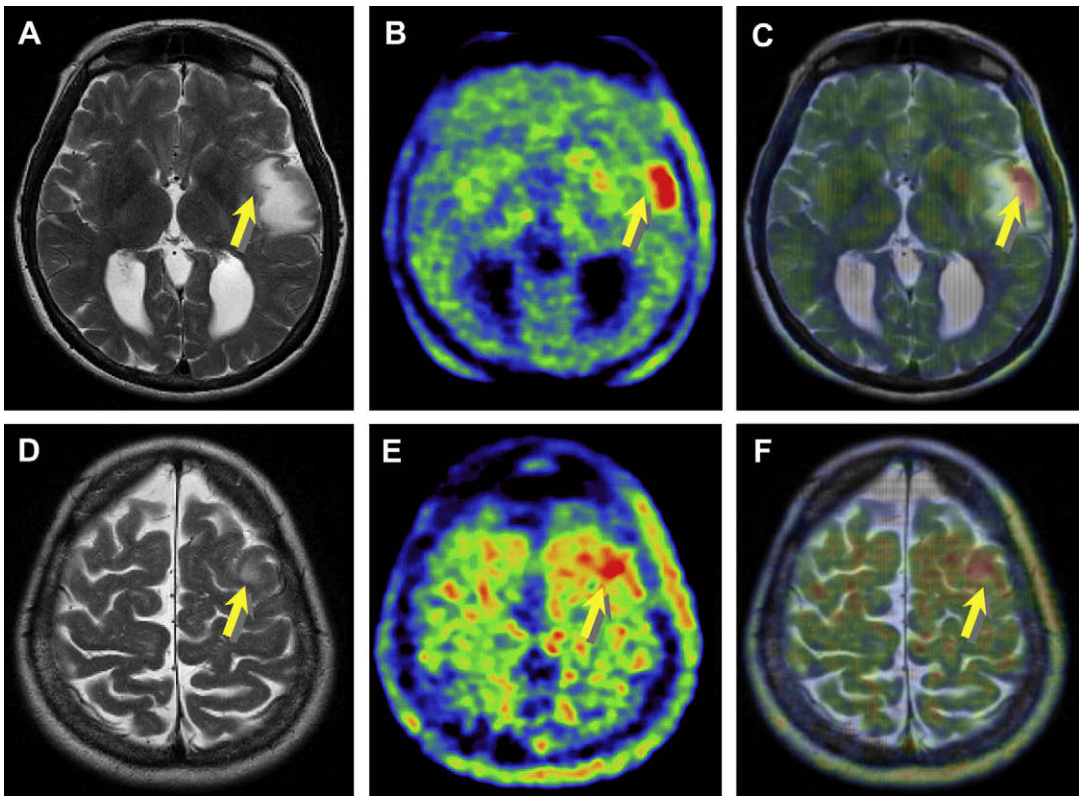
Example of a patient with a glioblastoma (WHO IV) (arrows) in the left temporal and frontal areas. The images shown on the top row (temporal area) correspond to gadolinium-enhanced, T2-weighted MR imaging (A), coregistered ^{18}F -FET (B), and fused PET/MR imaging (C) of the first study. The same images are shown in the bottom row for the frontal area (D, E, and F). The ^{18}F -FET PET study revealed an additional lesion missed on MR imaging. In addition, the T2-weighted MR image and the ^{18}F -FET PET show substantially different gross tumor volume extension for radiotherapy treatment planning.
